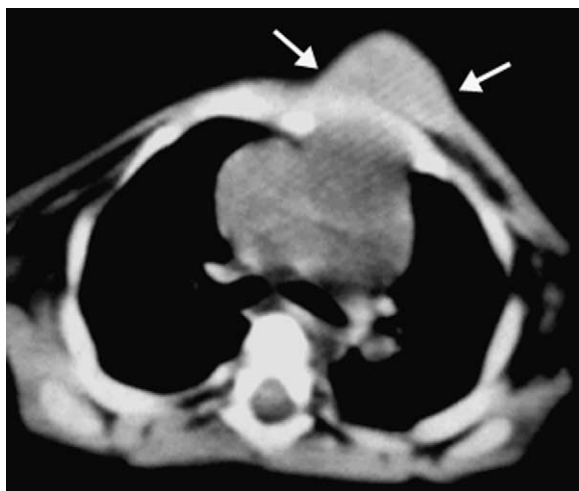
CT scan of the chest disclosed $2 \times 3 \times 3$ cm in size, oval mass in soft tissue density to the left of sternum (white arrows).
